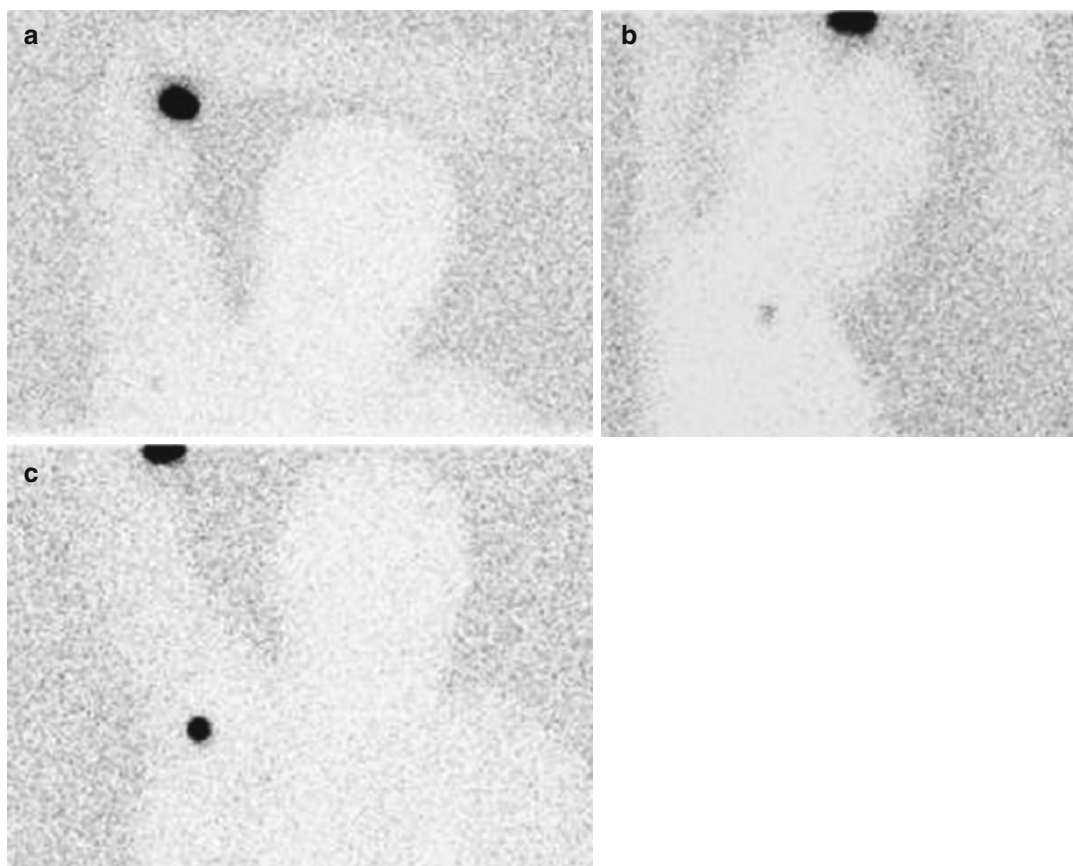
Sentinel lymph node localization in a 13-year-old boy with synovial sarcoma in the right antecubital fossa. Lymphoscintigraphy is performed after two intradermal injections of filtered ^{99m}Tc -labeled sulfur colloid in the antecubital fossa. Planar images are co-registered with transmission images for anatomic localization. (a) After
